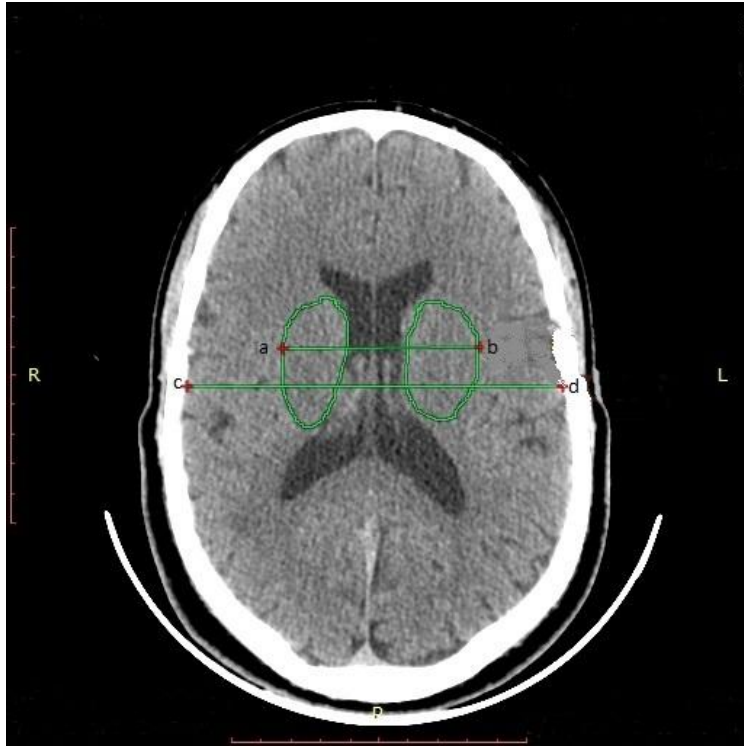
A CT image showing measurement Bi-caudate index (BCI); determined by measuring the lateral borders of head of caudate (a-b) and intracranial distance of the inner skull tables (c-d) at the same level.
